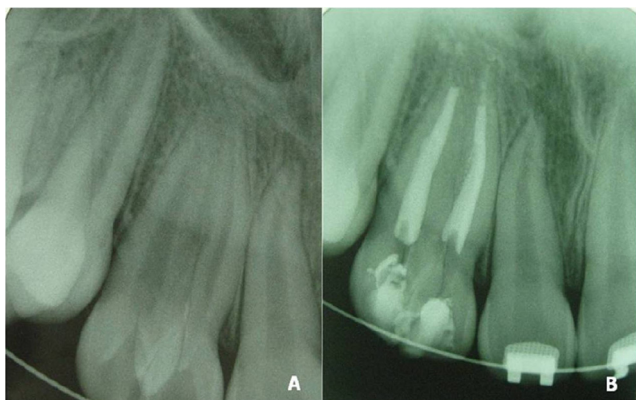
A) The initial radiographic: fusion of elements 12 and 13 was found. B) Endodontic treatment completed.
